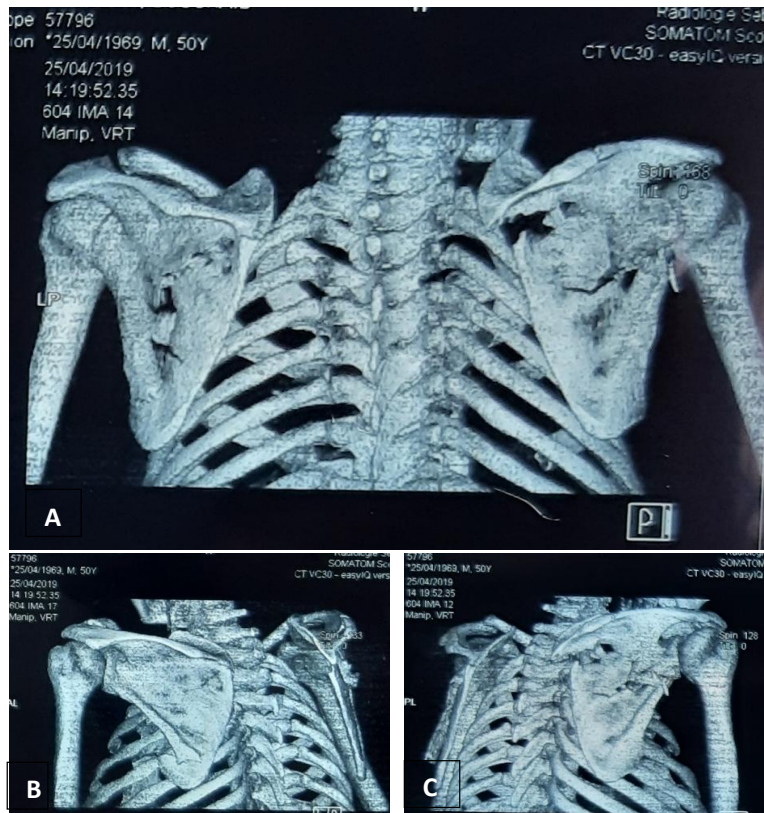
A. Computed tomography with 3D reconstruction showing the 2 shoulders, B. Comminuted fracture of the body of the scapula on the left, C. Comminuted fracture on the right with involvement of the lower part of the glenoid
